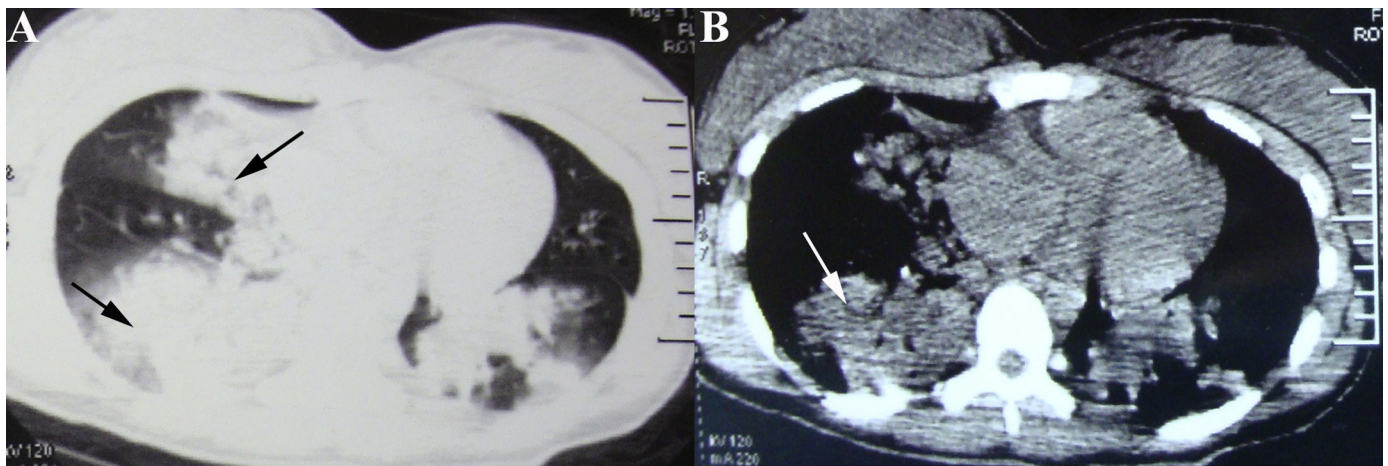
CT images at 5 days after the onset of pneumonia, showing irregular consolidations with interspersed small lucent areas in both lungs: A, black arrows; B, white arrow.
